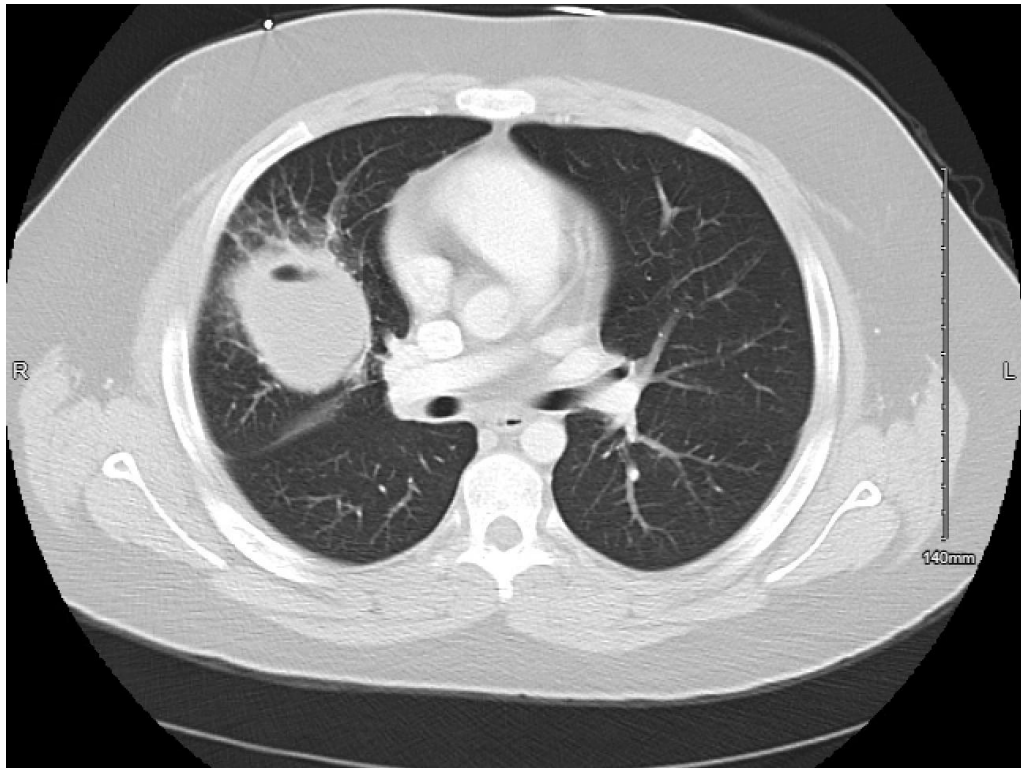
CT Axial slice of the chest. The chest CT demonstrates a 6.2-cm thick-walled gas-and-fluid collection in the right upper lobe, consistent with a pulmonary abscess.
